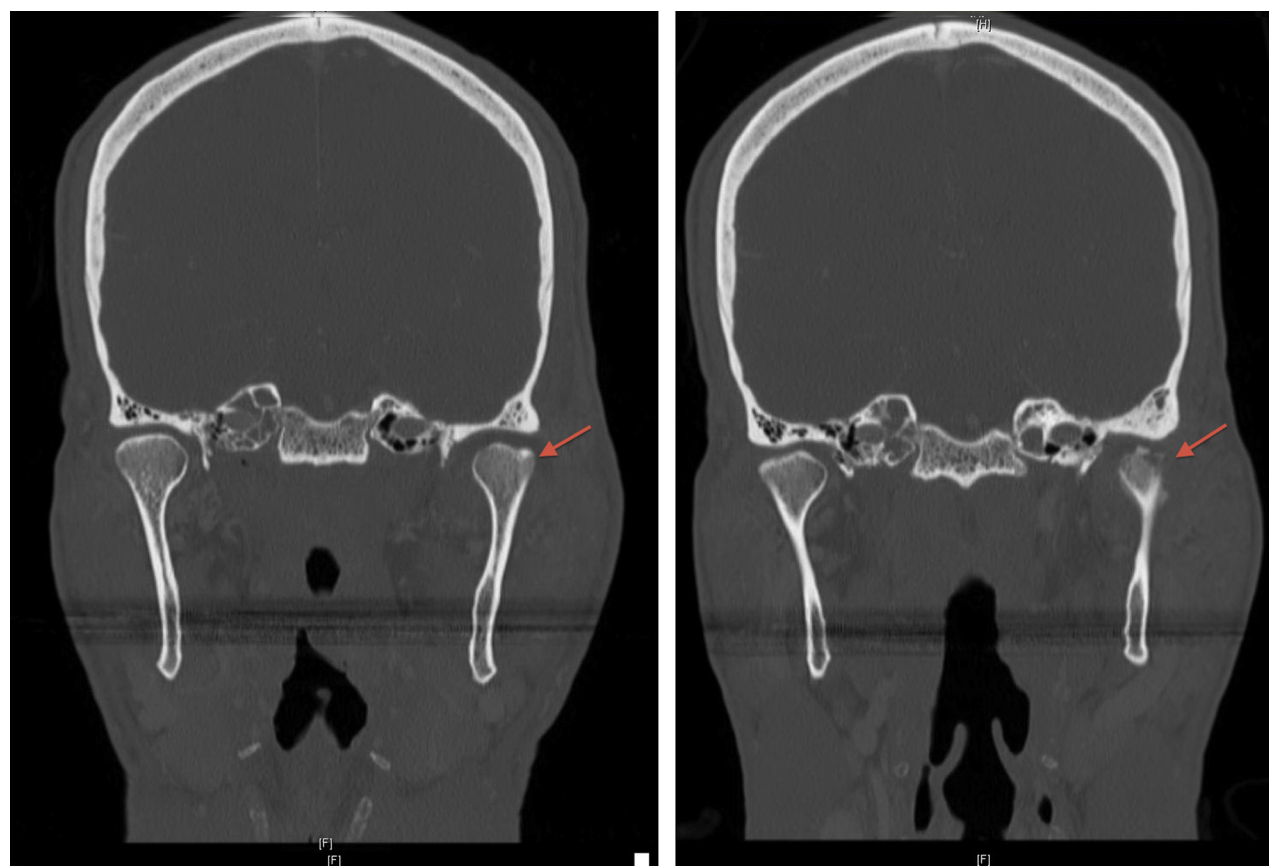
Case 1. *Left*, Preoperative (day 30) and *right*, postoperative (day 59) maxillofacial contrast-enhanced coronal computed tomograms show osteoarthritic changes of the left temporomandibular joint (arrows) at presentation and follow-up. The latter image also indicates resolution of the abscess and associated cervical lymphadenopathy.
